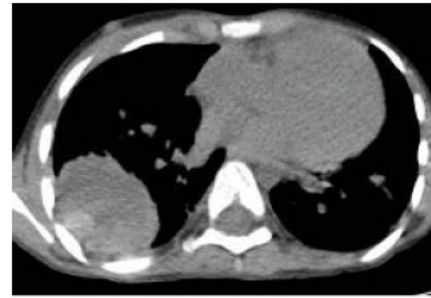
CT image with nodules
